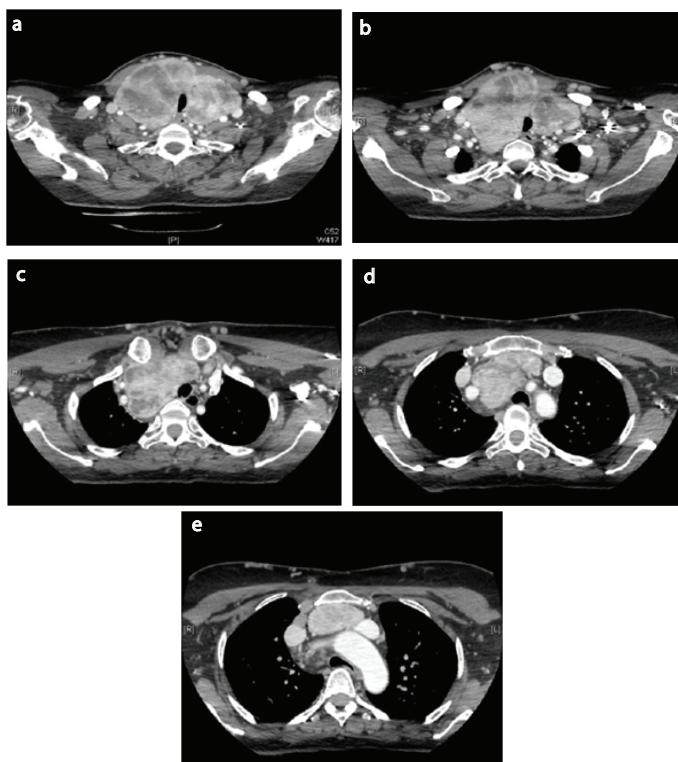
CT scan chest with I.V. contrast "different levels" showing massive enlargement of the thyroid gland with multiple heterogeneous hypodense nodules with retrosternal extension reaching the anterior mediastinum and subsequent vascular venous compression.
